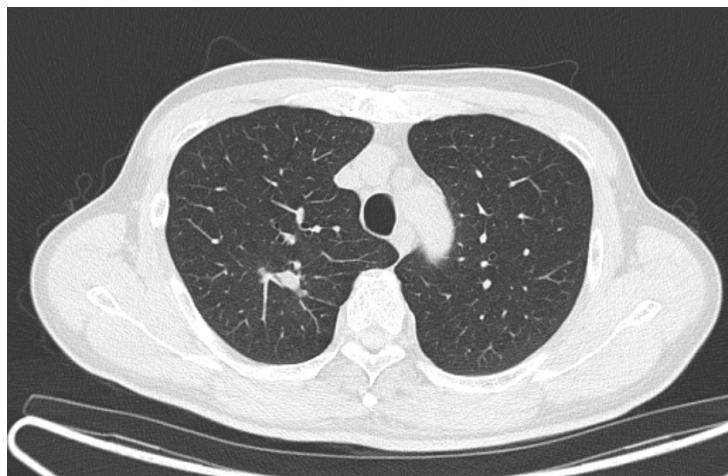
58 yo smoker with RUL 1 cm nodule, possibly representing an impacted airway, found on screening CT chest.
